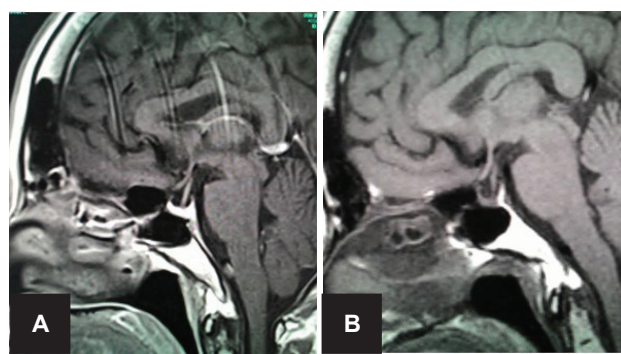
T1 weighted sagittal MRI image of the pituitary post contrast (A) 2015 and (B) 2004. Both showing a small pituitary gland which is pressed against the sellar floor with no internal hypoenhancement post-contrast.
